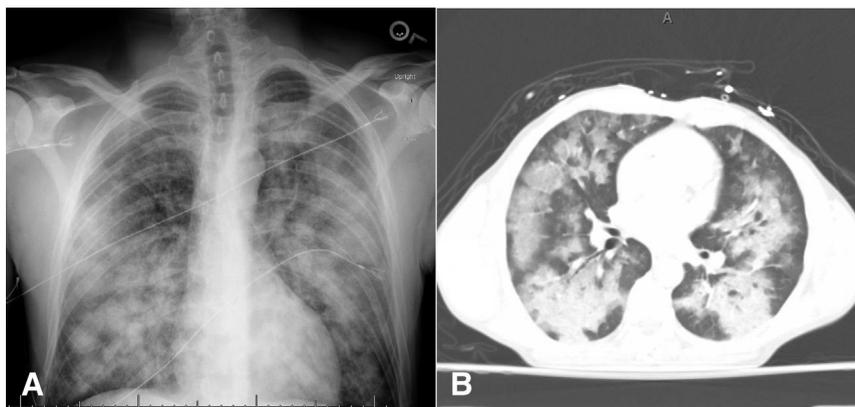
(A) Chest x-ray study with diffuse bilateral nodular infiltrates and (B) axial computed tomography image with extensive bilateral ground-glass opacities, consistent with acute respiratory distress syndrome.
